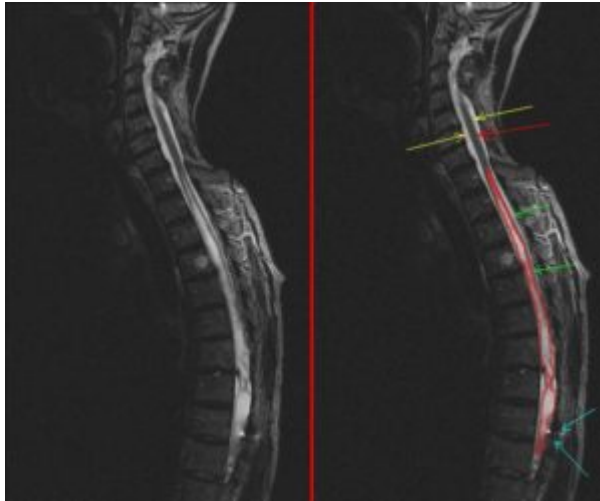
"MRI image of the sagittal thoracic spine with syringomyelia" by Lucien Monfils. License: [CC BY-SA 3.0](https://creativecommons.org/licenses/by-sa/3.0/)
